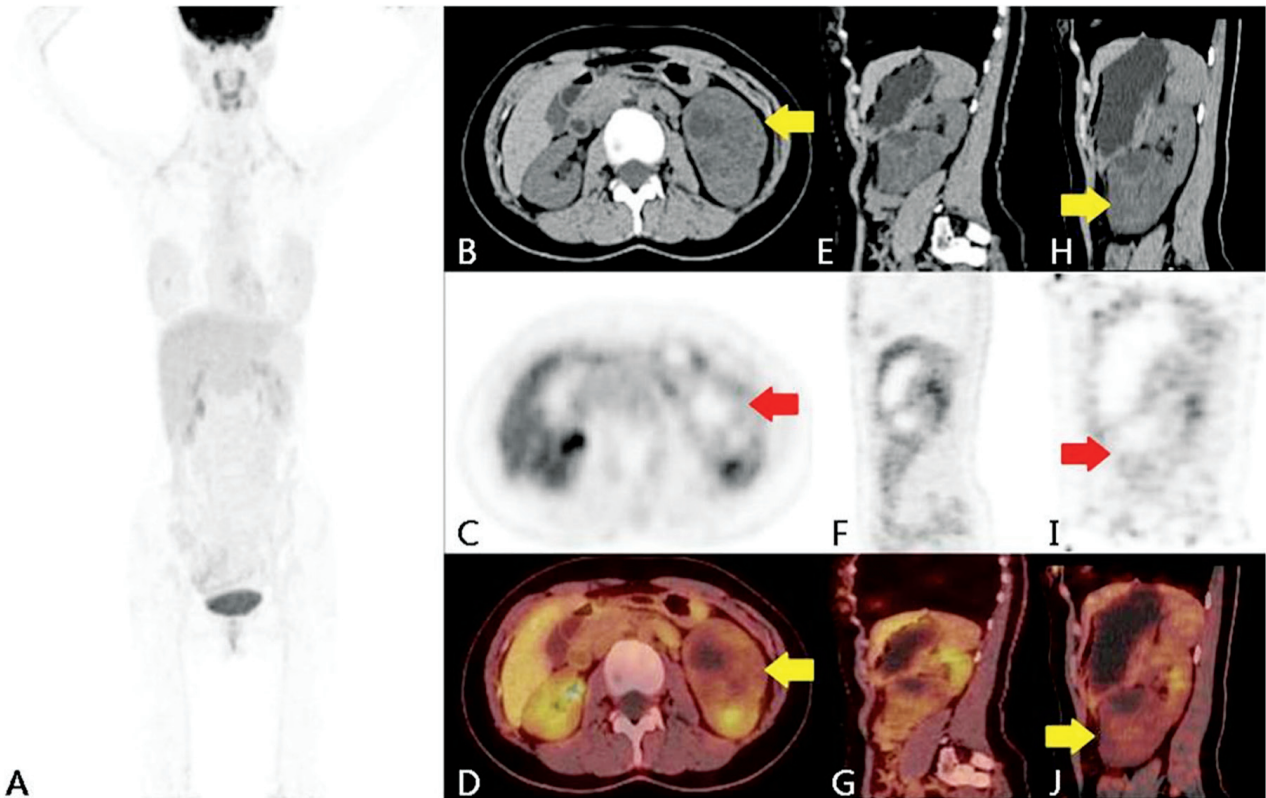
¹⁸F-labeled fluoro-2-deoxy glucose imaging (A-J) a mild FDG uptake (SUVmax 2.6) in the mass of the left kidney (arrow), delayed abdominopelvic PET/CT scan showed still mild FDG uptake (SUVmax 1.8) (H-J).
